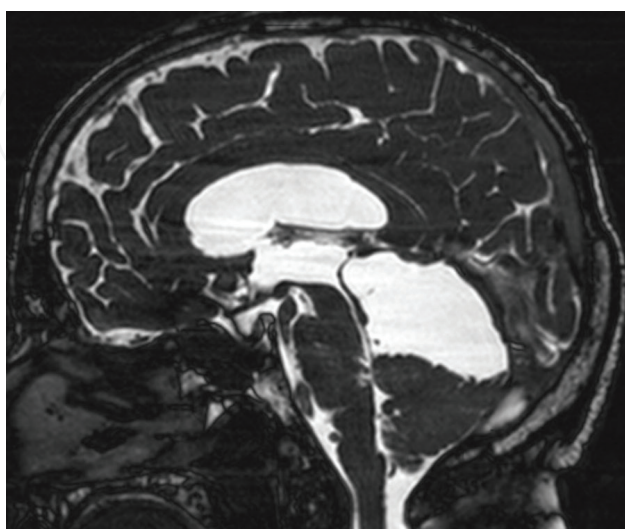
Arachnoid cyst with compression of the CSF pathway (MRI scan TRUF1 sequence). In this case, a cystostomy and simultaneous ETV were performed.
